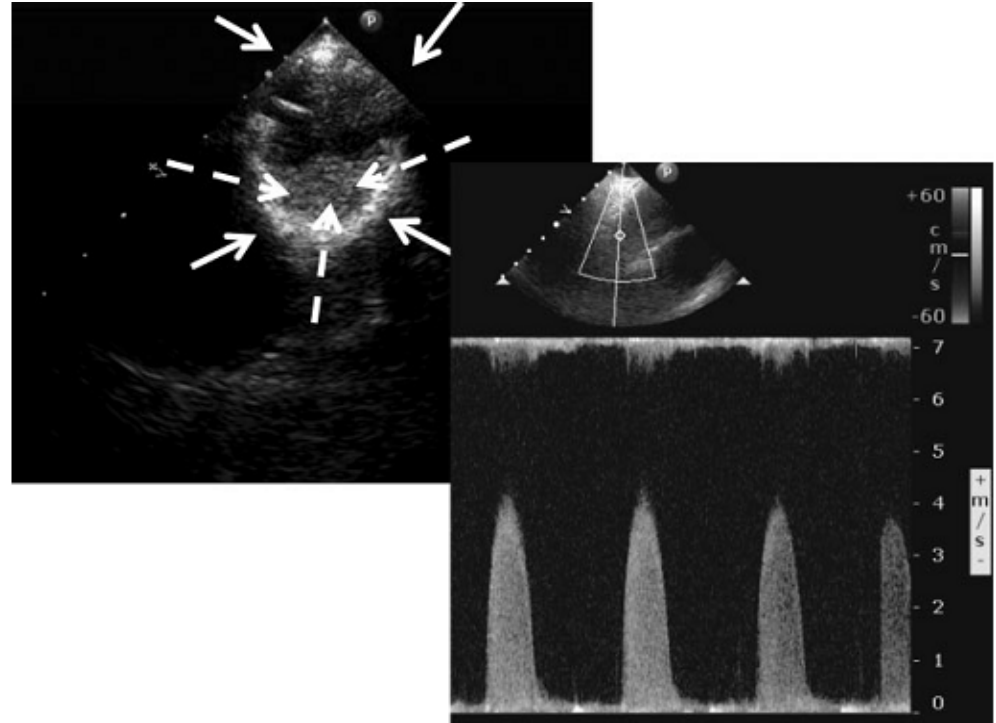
Intracardiac echocardiogram shows the struts of the Sapien valve stent (solid arrows) and the thrombus on the prosthesis leaflets (dashed arrows). Intracardiac echocardiography Doppler measured a transvalvular aortic velocity close to 4 m/s.
